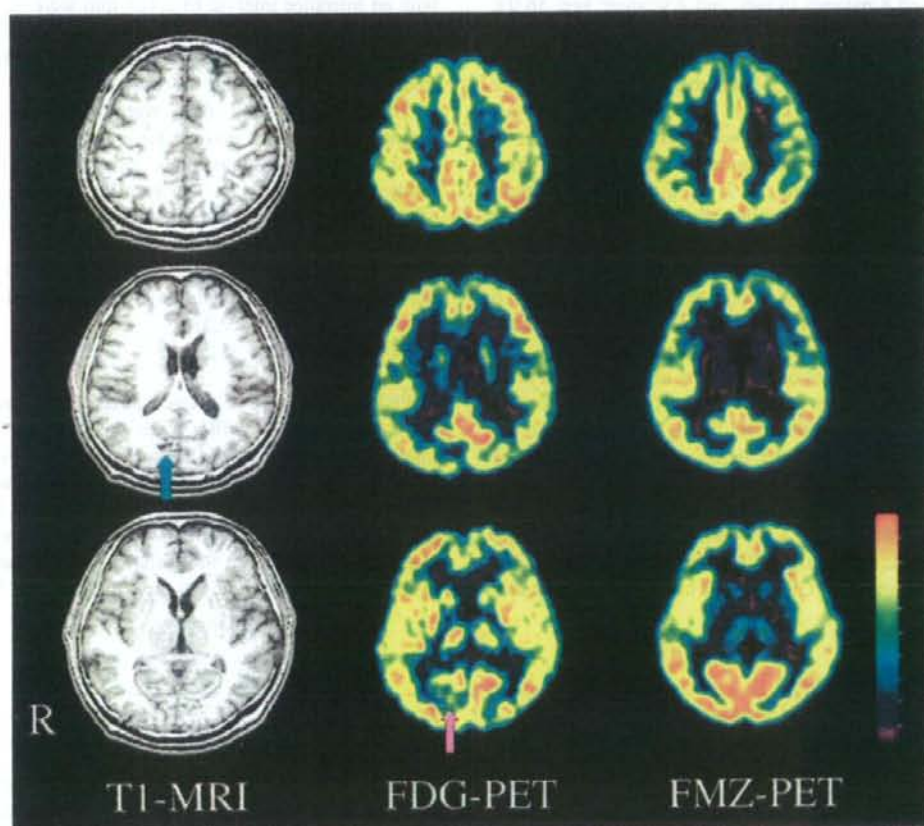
T1-weighted magnetic resonance (MR) images (left), ^{18}F -fluorodeoxyglucose (FDG)-positron emission tomography (PET) images (middle), and ^{11}C -flumazenil (FMZ)-PET images (right) of patient 4. MRI revealed neuronal loss of the right cuneus (green arrow), with decreased FDG and FMZ uptake. The cerebral glucose metabolism decreased in the right striate cortex (pink arrow), while no decrease was observed in the FMZ binding in the striate cortex.
